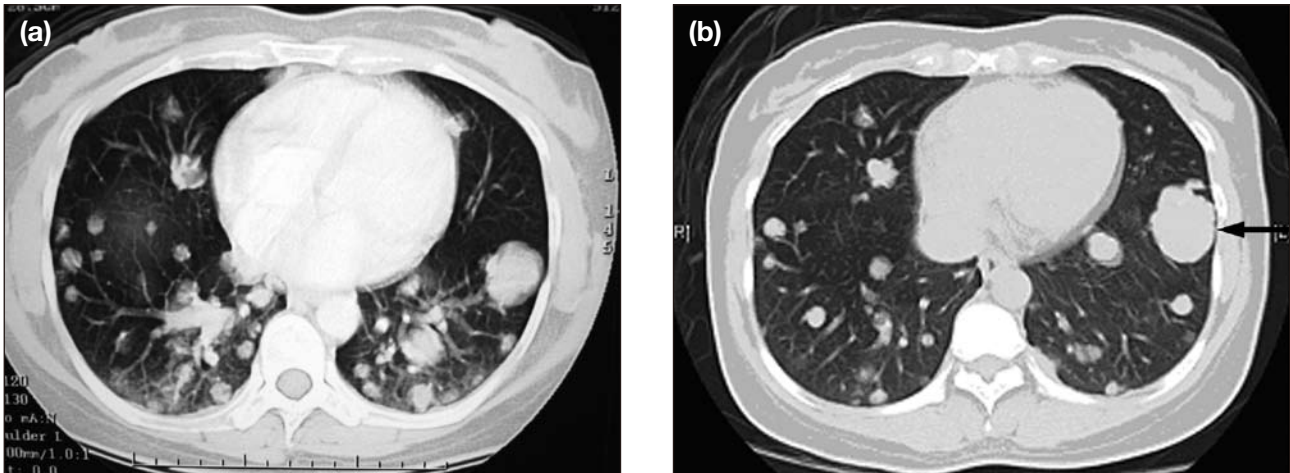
Computed tomography of the thorax performed in (a) 2006 showing multiple lung lesions of variable sizes; and (b) 2007 showing a mild increase in the size of one of the lung lesions (arrow). The apparent reduction in the number of lesions in 2007 and the difference in image quality are due to motion artifacts and imaging on a new computed tomography scanner in 2007.
